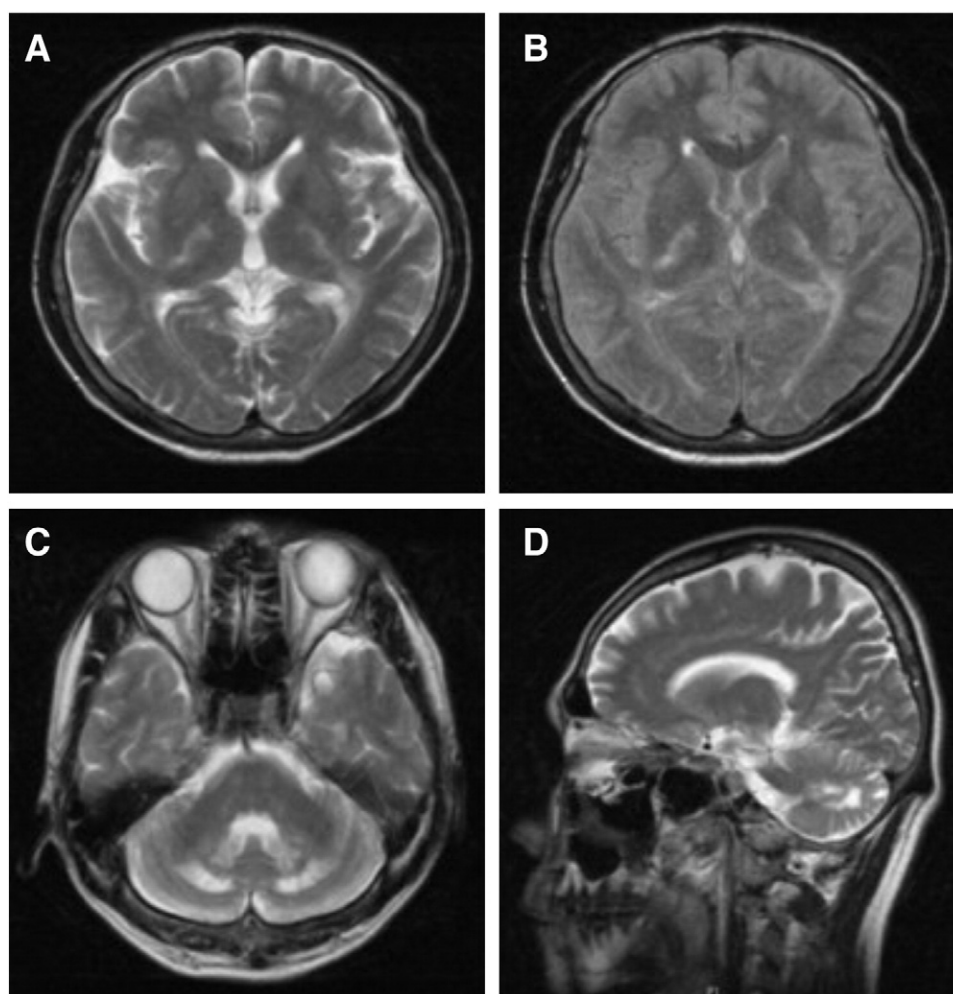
Brain MRI: axial T2-weighted image (A) and Fluid Attenuated Inversion Recovery-weighted image (B) show high signal intensity symmetrically in the posterior limb of the internal capsule. Axial T2-weighted image (C) shows high signal intensity symmetrically in the dentate nucleus of cerebellar hemisphere. Midsagittal T2-weighted image (D) shows hyperintense signals in cerebellar hemisphere and mild cerebellar atrophy.
